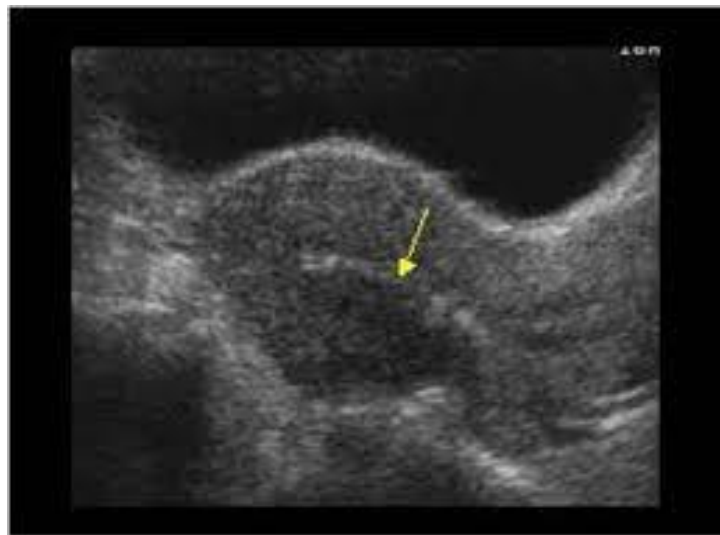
shows ultrasound image of subserosal fibroids.Jane Bates 2010
